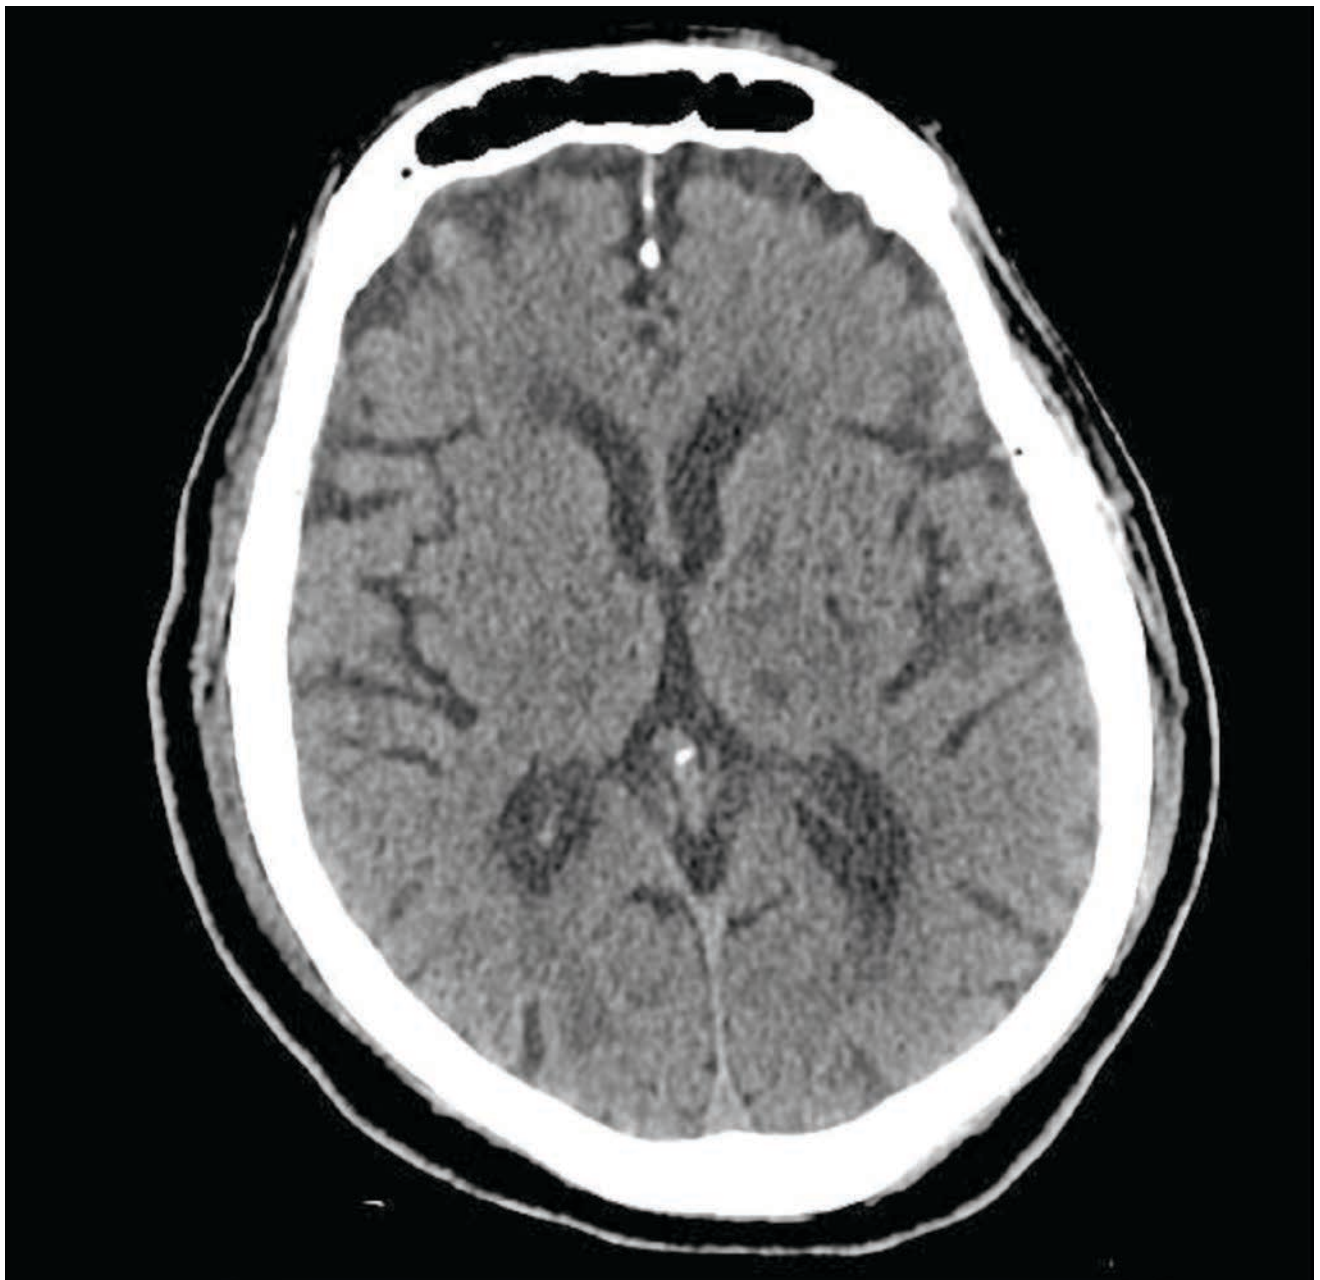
CT scan without acute findings
